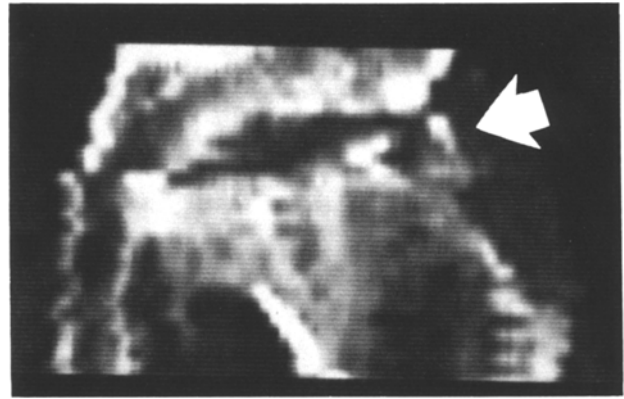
Advanced osteoarthritis. Reformatted image in the coronal plane demonstrates marked flattening of the femoral head in association with superior migration, osteophytosis, and fragmentation (*arrow*). Such images can be obtained in any desired plane from axially-acquired CT data within several seconds
